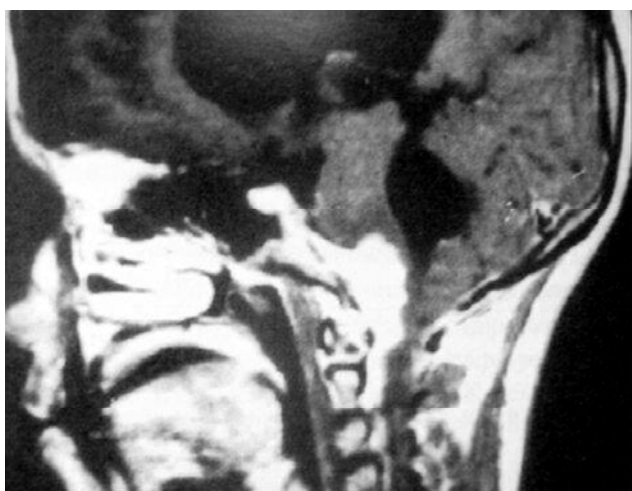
Contrast-enhanced MRI shows the large premedullary lesion
